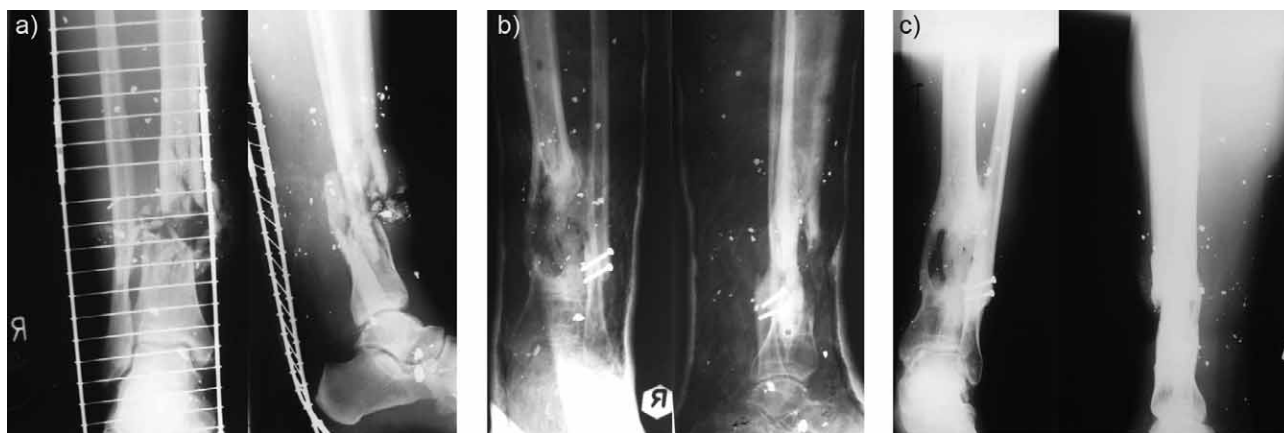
A 34-year old man sustained a type IIIB open tibial fracture as a result of war injury. Anteroposterior and lateral radiographs show a) the fracture after initial injury, b) ten months after central bone grafting (stabilisation with above the knee cast), and c) five years after central bone grafting.
